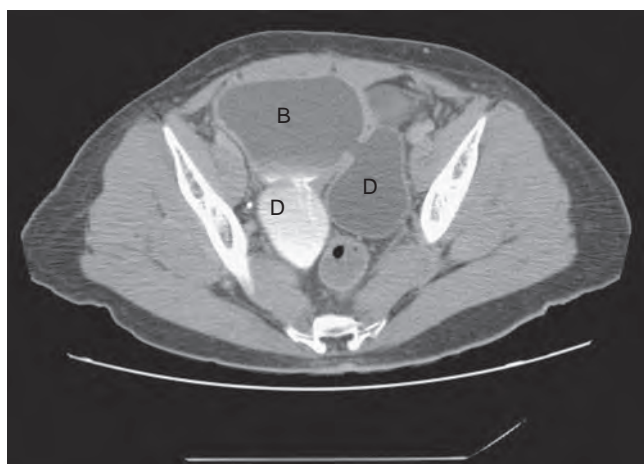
Computed tomography urogram of the abdomen/pelvis of a patient with Williams syndrome and four bladder diverticula. Laparoscopic bladder diverticulectomy of diverticula can be performed in a single setting in experienced hands. Contiguity between true bladder (B) and two posterior bladder diverticula (D) is demonstrated.
